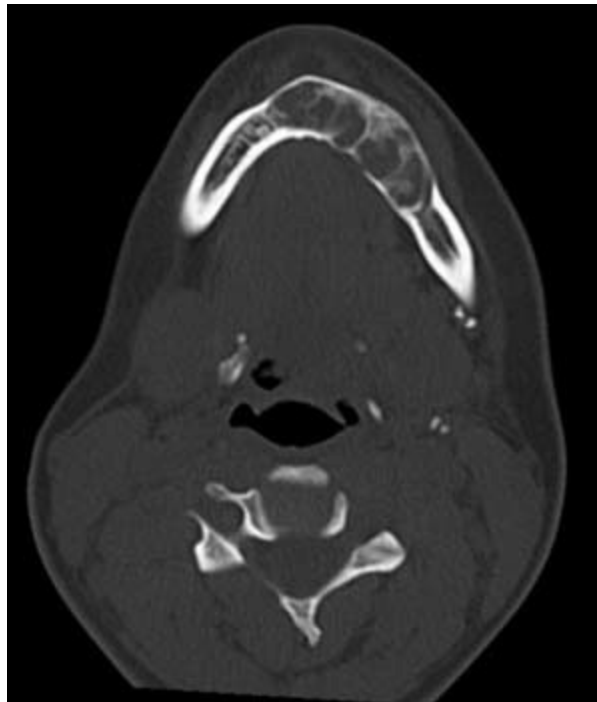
Axial view of CT showing the extent of the central giant cell lesion of the same patient from Fig. 3.9. This plane reveals a multilocular growth pattern with thinning of both the buccal and lingual cortical plates.
